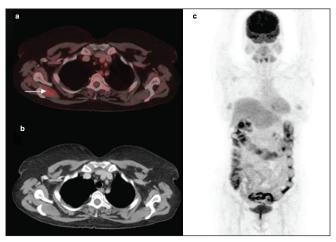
Whole-body PET/CT, Transaxial fused (a), corresponding CT (b) images revealing mild 18F-FDG uptake in the right supraspinatus muscle (arrow). Maximum intensity projection image (c) revealed multiple foci of abnormal increased FDG uptake in the large bowel.
